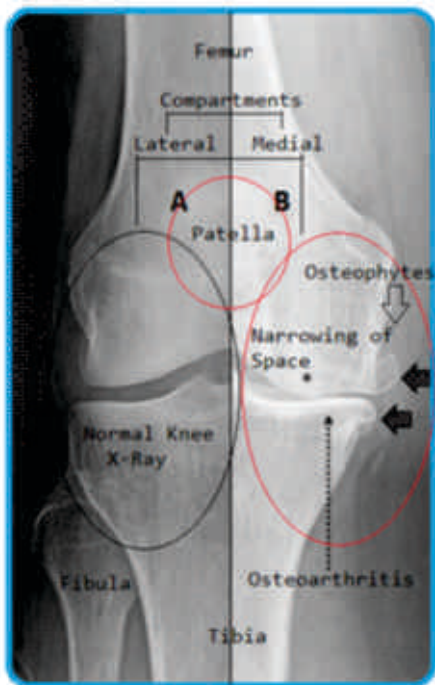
X-Ray Knee AP View (Standing) Normal vs Osteoarthritis
